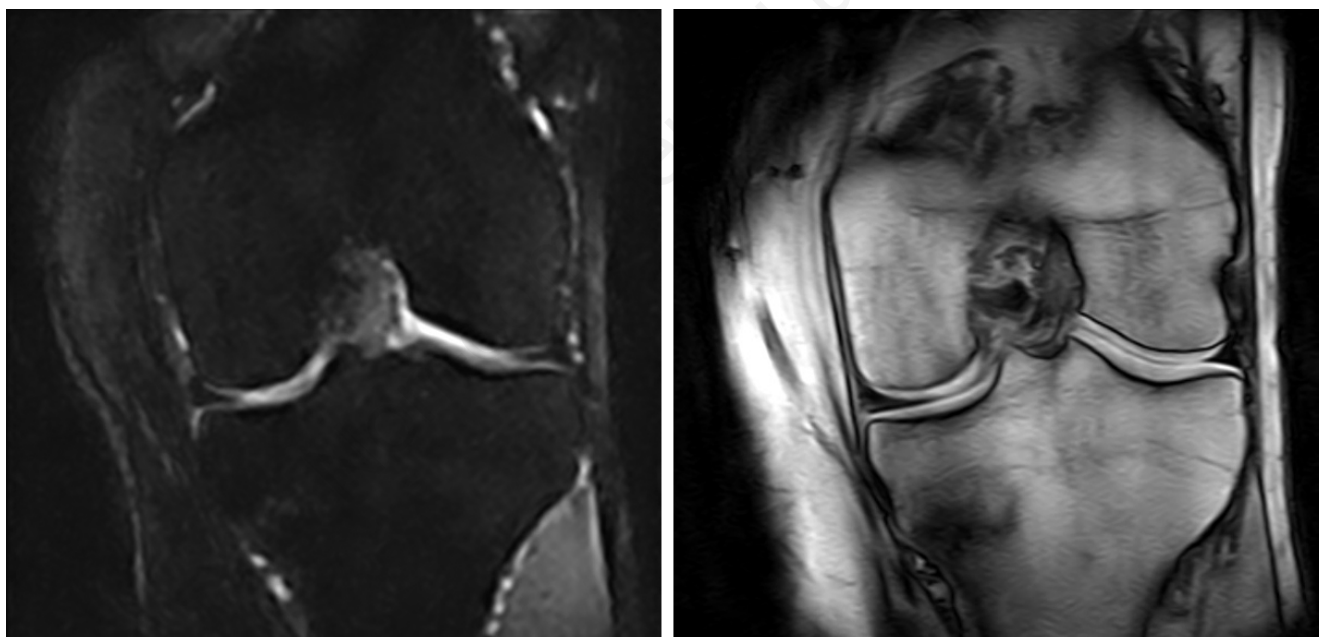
Magnetic resonance imaging showing resolution of the bone marrow edema.
